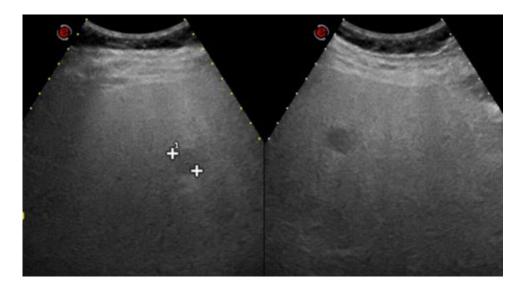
The ultrasound examination performed 6 year after completion of chemotherapy showed the onset of 2 small hypoechoic hepatic nodules in a background of hepatic steatosis.
